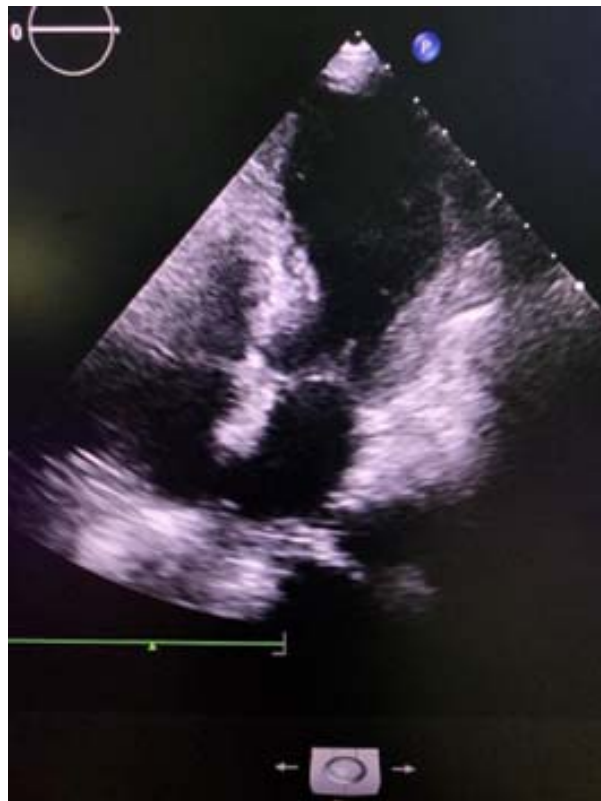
Echocardiogram showing a normal-sized left ventricle with anterior and anteroseptal hypokinesia and apical akinesia.
